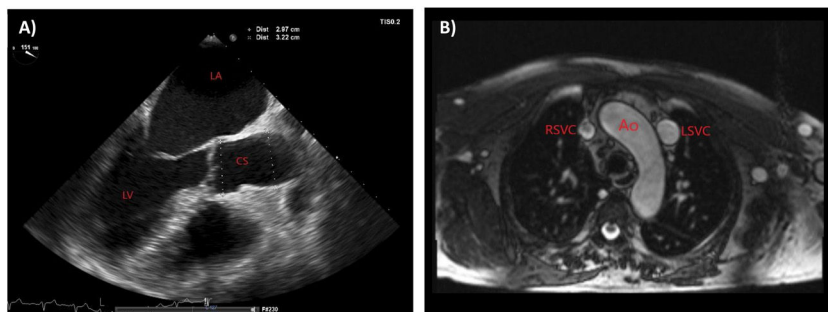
Imaging findings. (A) Transthoracic echocardiography showing a markedly dilated coronary sinus, and enlargement of left and right atrium. (B) Magnetic resonance imaging in transversal view showing a bilateral superior vena cava with a right superior vena cava and a persistent left superior vena cava. Ao, aorta; CS, coronary sinus; LA, left atrium; LSVC, left superior vena cava; RA, right atrium; RSVC, right superior vena cava.
